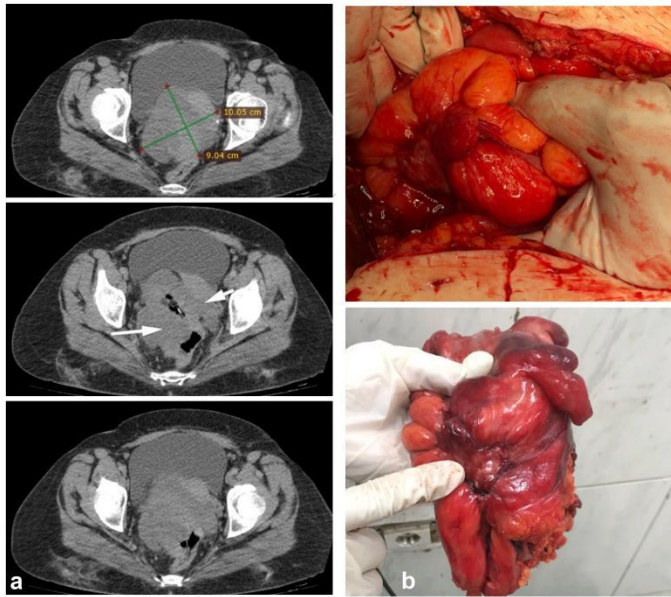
This figure shows the radiological and surgical images of sigmoid colon cancer. (a) Axial CT pelvis with contrast reveals hyperdense mass lesion in the sigmoid colon (white arrows) measures about 10x8 cm with narrowing of the lumen (T3 N0 M0). (b) Photography shows presence of large mass in sigmoid colon.
